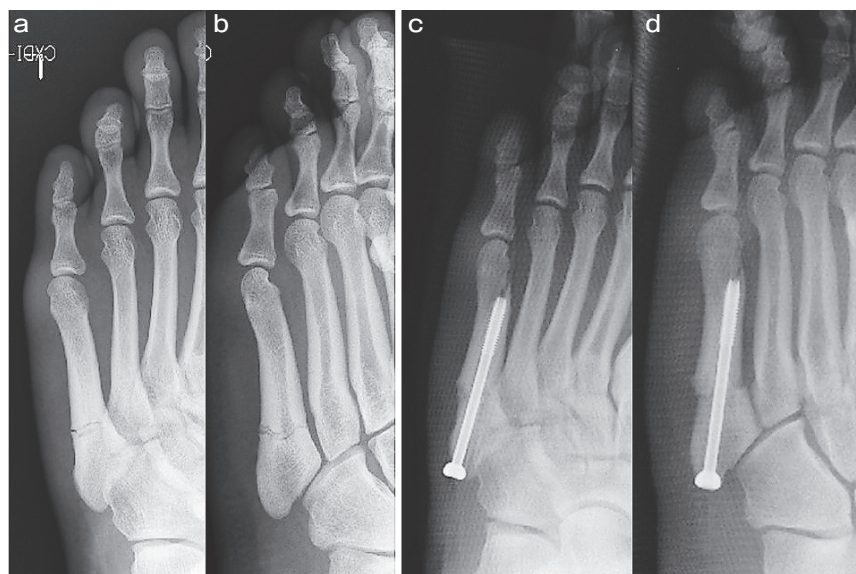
(Case 1) A-P (a) and oblique (b) preoperative foot X-ray images, Jones fracture was observed in zone 3 of the left proximal fifth metatarsal; A-P (c) and oblique (d) postoperative foot X-ray images, Intramedullary screw fixation was performed using a 4.5 mm-diameter cannulated cancellous screw.
